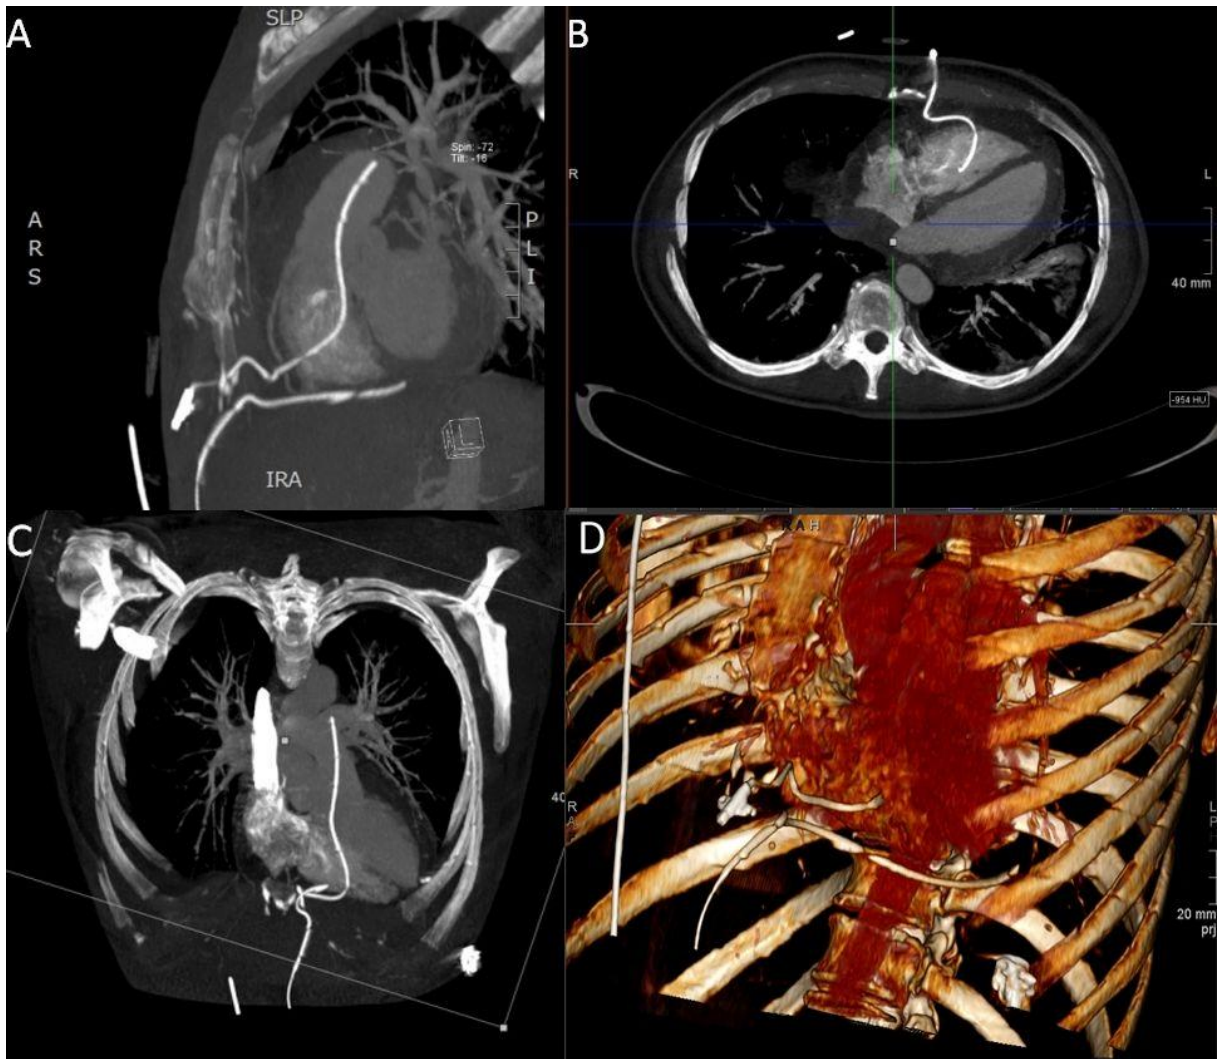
CT angiography scan
